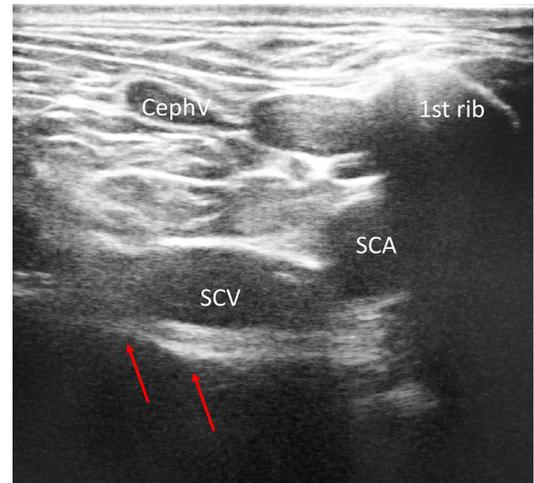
Ultrasound probe position and visualization of the SCV (supraclavicular view). The SCV is visualized in longitudinal view just in front of the subclavian artery (SCA) but the pleura (indicated by red arrows) is just behind the posterior wall of the vein. The cephalic vein (CephV) is just crossing and reaching the SCV
